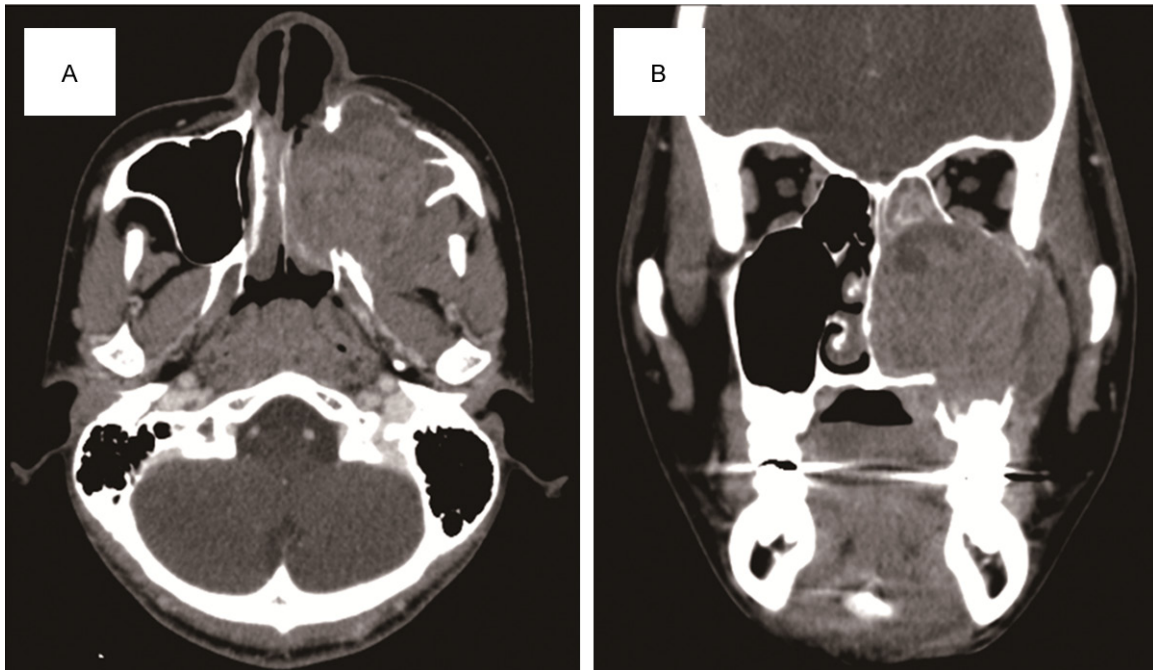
Computed tomography. Axial (A), and coronal (B) images. A visible mass is centered in the left maxillary sinus, causing degeneration in the surrounding bones. The mass shows soft tissue density and is sized 55 × 45 × 40 mm.
